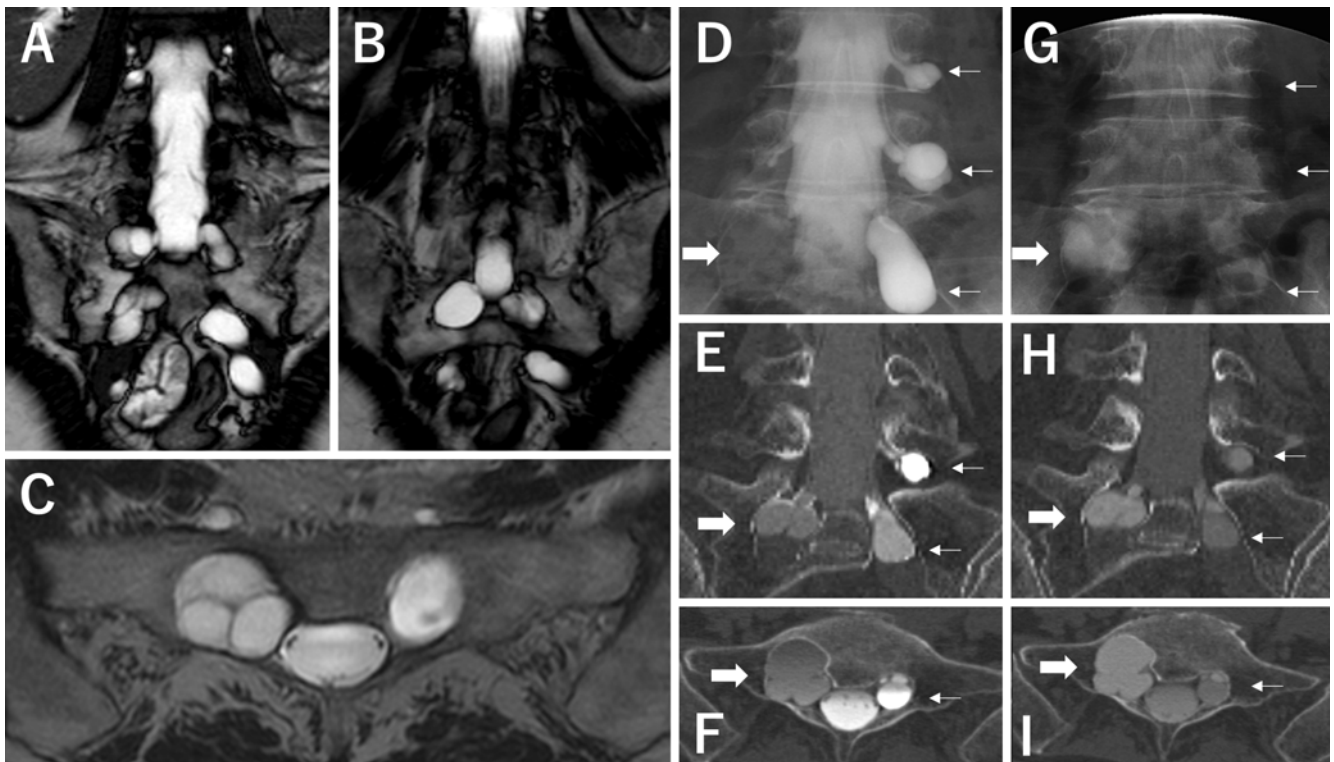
Preoperative T2 weighted coronal (A, B) and axial (C) magnetic resonance imaging displaying multiple cystic lesions at the lumbar and sacral levels. Myelography (D) and computed tomography (E, F) immediately after injection and 6 h later (G, H, I) demonstrated that a cyst in the left L4, L5, and S1 regions (small arrow) is enhanced immediately and washed out 6 h later, whereas a cyst in the right S1 region (large arrow) is not enhanced immediately (filling defect sign) but enhanced 6 h later (delayed filling sign/retention sign).
